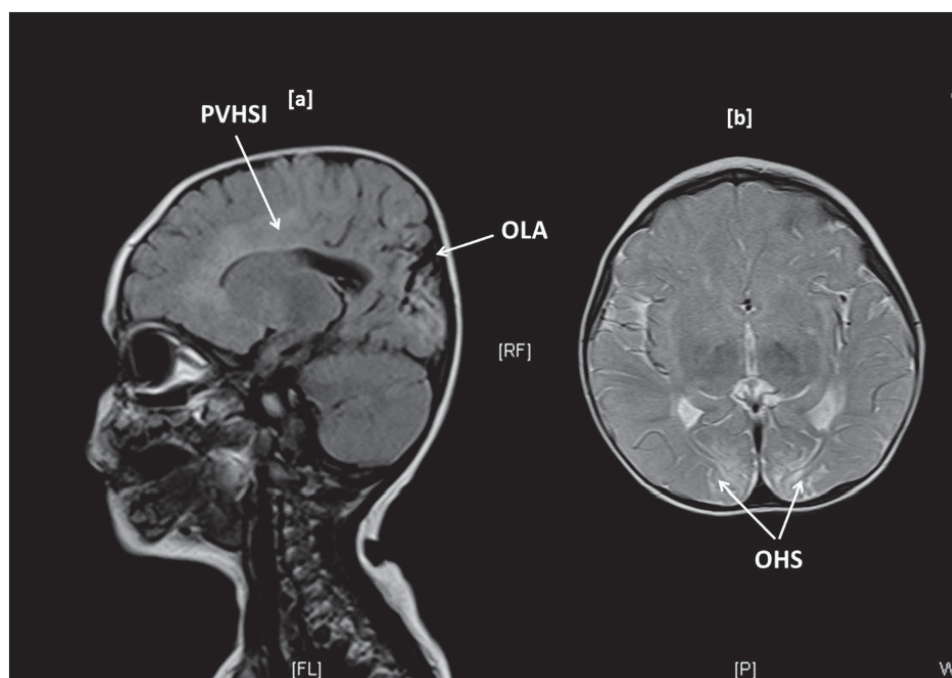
MRI scan of an 1- year- old diagnosed with transient CHI showing occipital lobe atrophy and periventricular high signal intensities (35)
